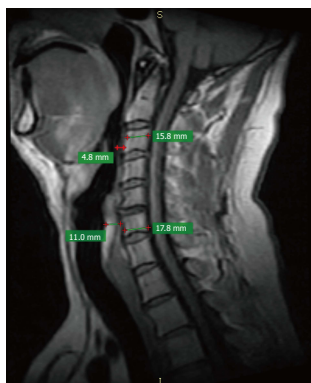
Preoperative radiograph showing retropharyngeal/prevertebral soft tissue at the level of C2 vertebral body and at the level of C6 vertebral body.
